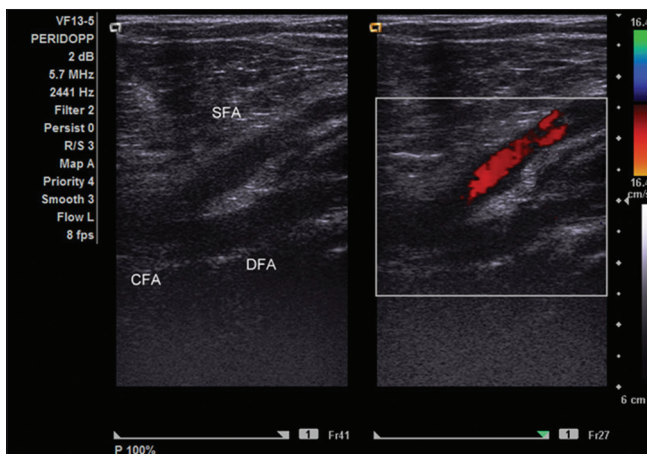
Longitudinal grayscale and color Doppler images of acute thrombosis of common femoral artery and deep femoral artery with normal color flow in superficial femoral artery
